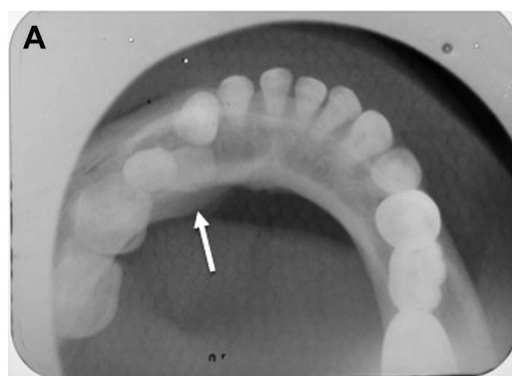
Radiographic images of the patient. (A) Mandibular occlusal radiograph revealing a prominent lingual cortical plate expansion from tooth #33 to #35 (arrow). (B) Panoramic radiograph demonstrating an impacted tooth #34 and a large well-defined, radiolucent lesion surrounding the crown of tooth #34. The radiolucent lesion measured approximately 3.5 × 1.9 cm in diameter and extended from the periapical area of tooth #31 to the mesial aspect of tooth #36.
